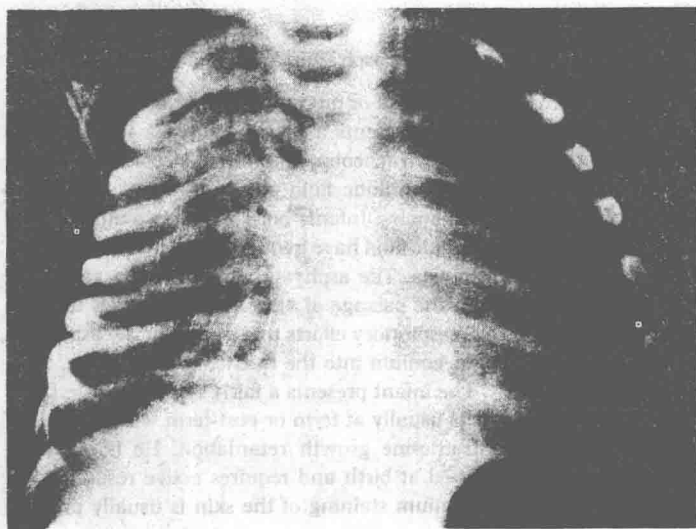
Chest radiograph of an infant with meconium aspiration. Note the coarse irregular densities particularly on the right side.
